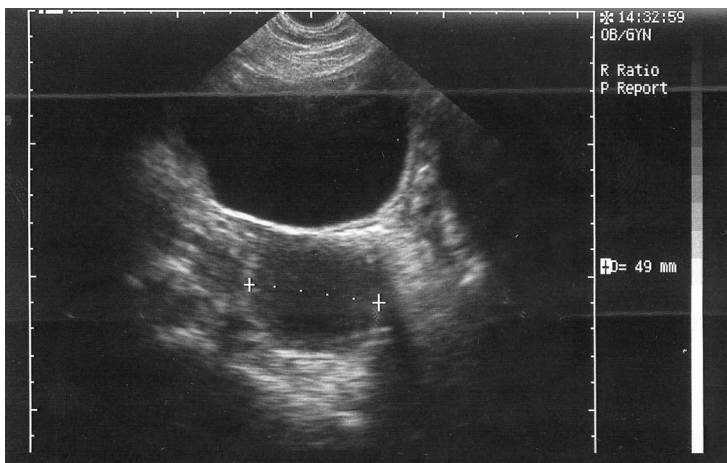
Transabdominal ultrasound 3 days after vaginal hysterectomy showing characteristic appearance of vaginal vault haematoma.
